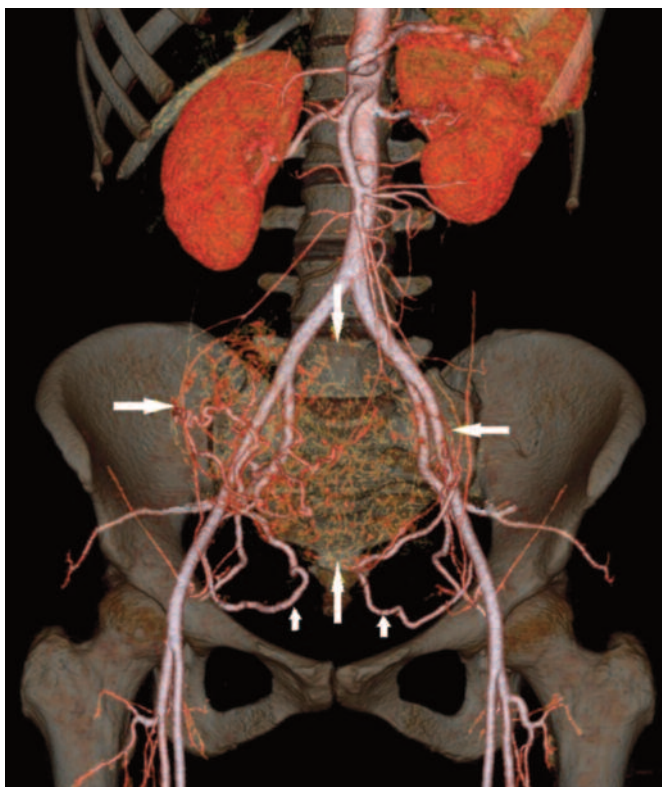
Pelvic CT angiography image of a 35-year-old patient with intramural hypervascular myoma 12 cm in diameter. The branches of the uterine arteries separating from the internal iliac artery (small arrow) and feeding the myoma (big arrow) are clearly seen.
